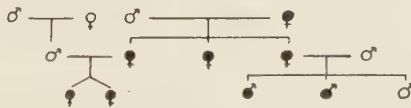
Faber's* 1937 radiographic findings of os tibiale in 3 generations.
